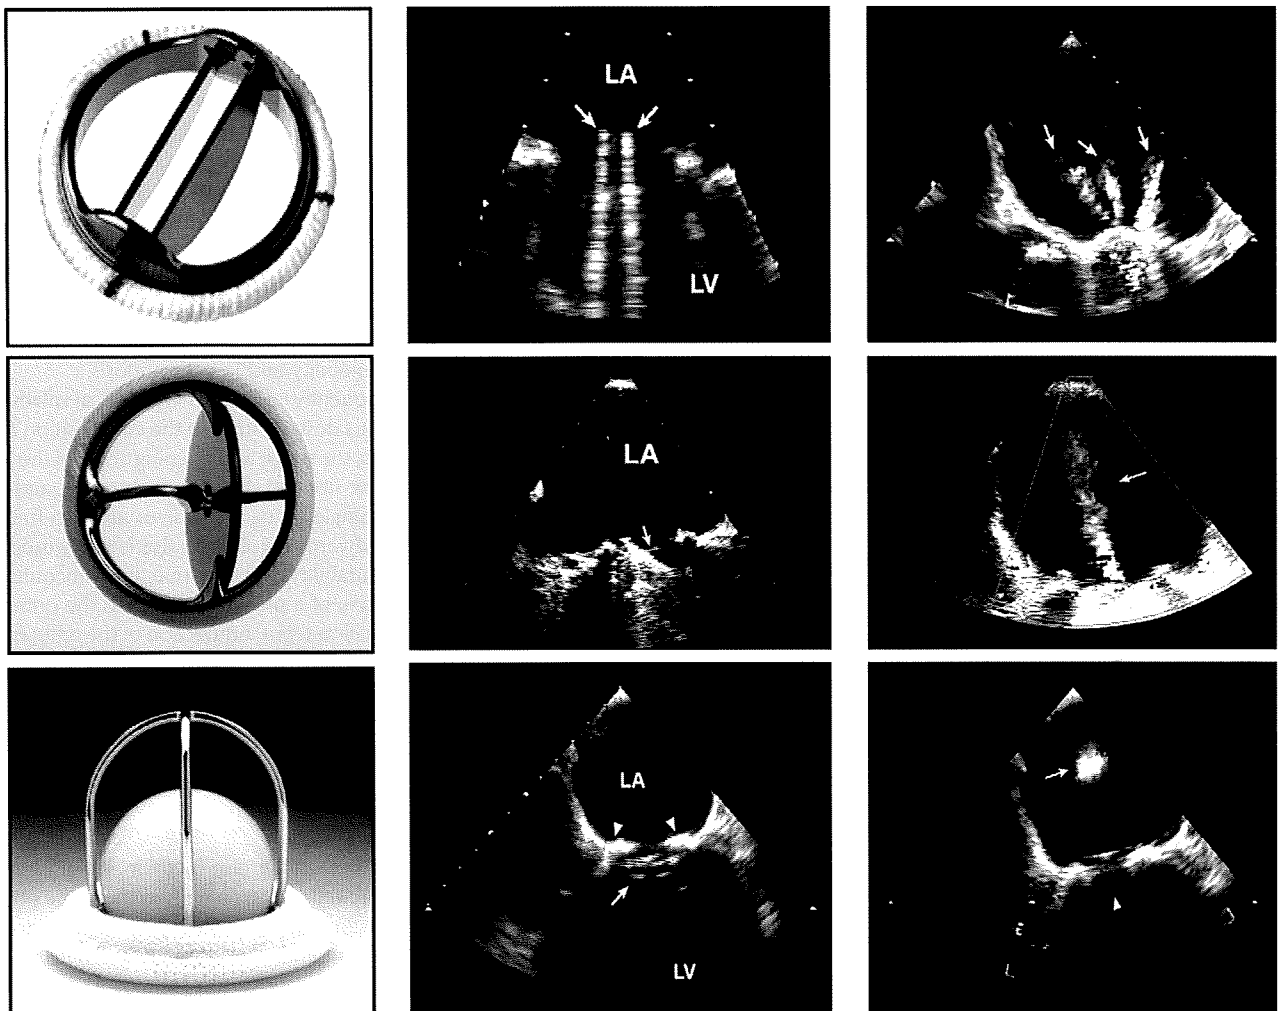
Examples of bileaflet, single-leaflet, and caged-ball mechanical valves and their transesophageal echocardiographic characteristics taken in the mitral position in diastole (*middle*) and in systole (*right*). The *arrows* in diastole point to the occluder mechanism of the valve and in systole to the characteristic physiologic regurgitation observed with each valve. Videos 1 to 6 show the motion and color flow patterns seen with these valves. [View video clips online.](#)
